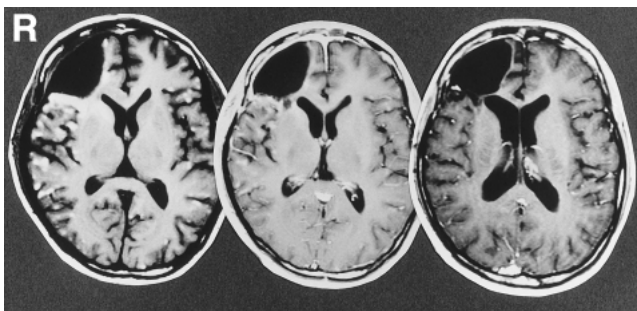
Axial T_1 -weighted magnetic resonance images with gadolinium just after the operation (left), 1 month after the operation (center), and 6 months after the operation (right) showing rapid disappearance of the lesions.
